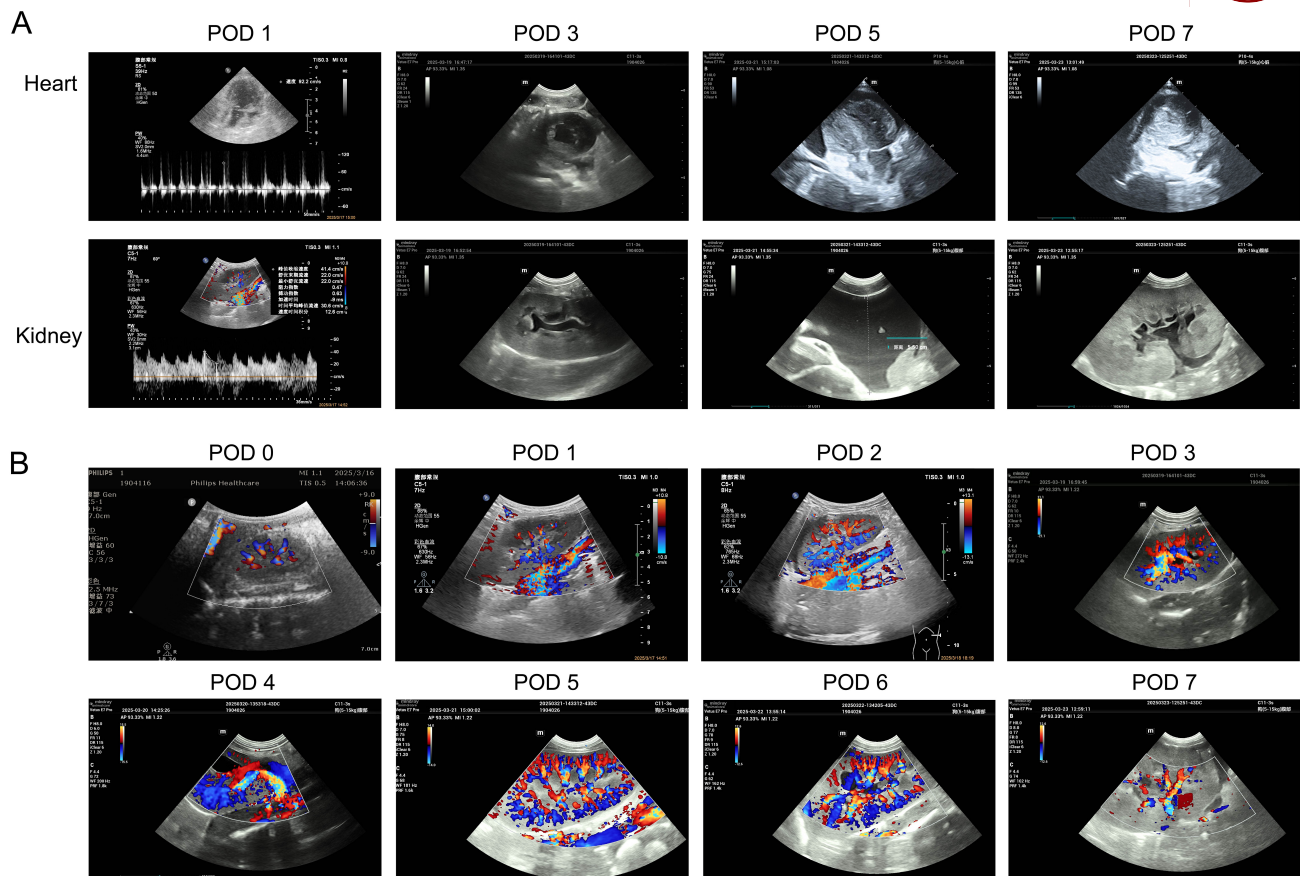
Imaging and quantitative analysis of functional changes in combined heart–kidney xenografts post-transplantation. (A) Representative ultrasound images of the transplanted heart and kidney at different postoperative time points (POD 1, POD 3, POD 5, and POD 7). (B) Renal Doppler ultrasound showing blood flow changes from POD 0 to POD 7.
